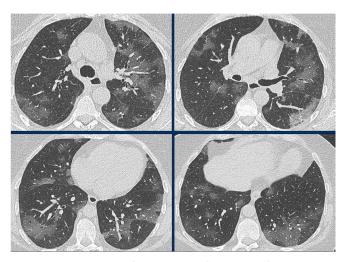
Impairments over CT Image [4]
